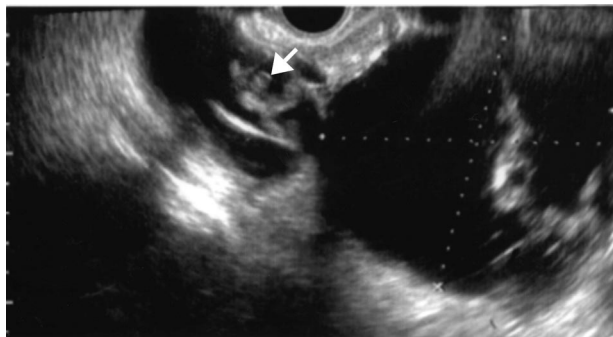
Ultrasound appearance of appendix (white arrow) and splenic tissue with adjacent pelvic tissue and adhesions. We considered adhesions as wall of the cystic pelvic mass and splenic tissue, appendix, and adjacent tissue as papillary vegetations.
